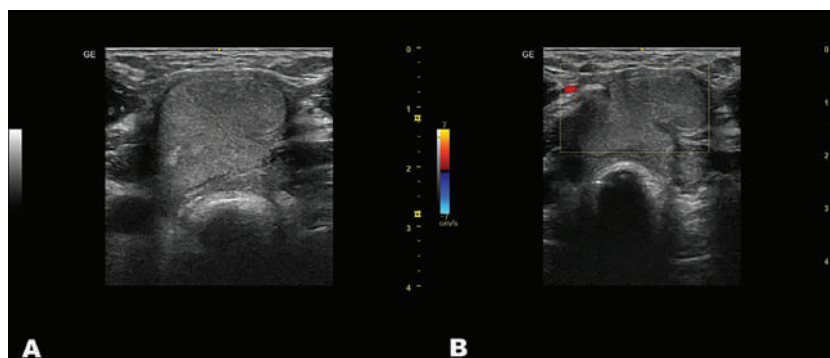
Ultrasonographic appearance of persistent oxidized regenerated cellulose in the thyroidectomy bed after total thyroidectomy. (A) Gray-scale neck ultrasonography demonstrating a hypoechoic, solid-appearing lesion located in the thyroidectomy bed. (B) Color Doppler ultrasonography showing that the same lesion is avascular.
